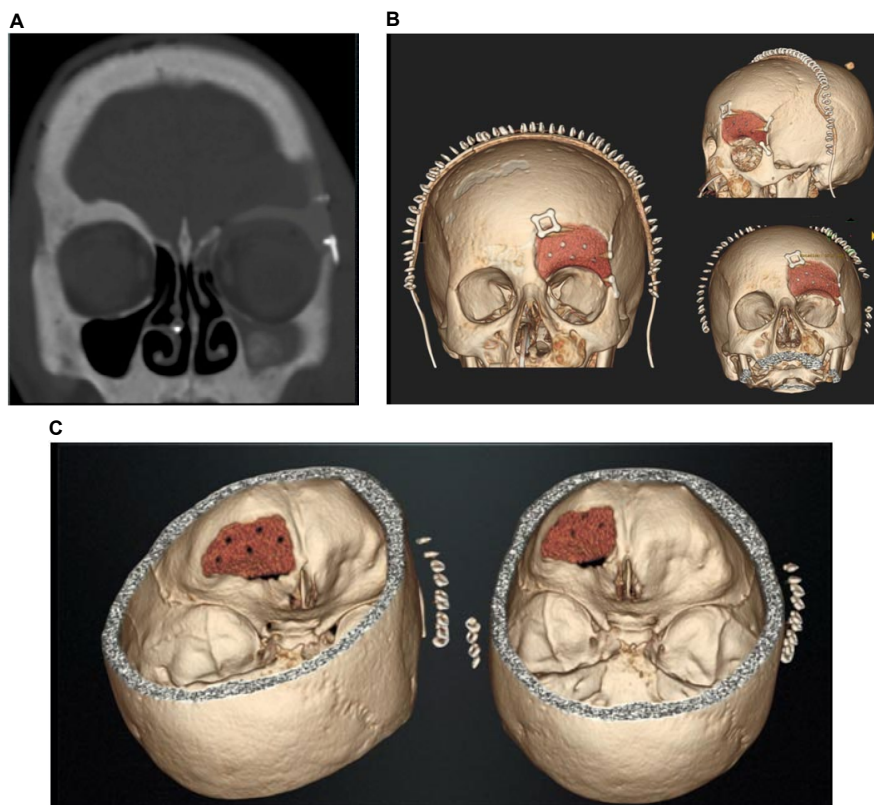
Immediate post-operative CT scan (A) and tridimensional reconstruction of the prosthesis (B and C).
